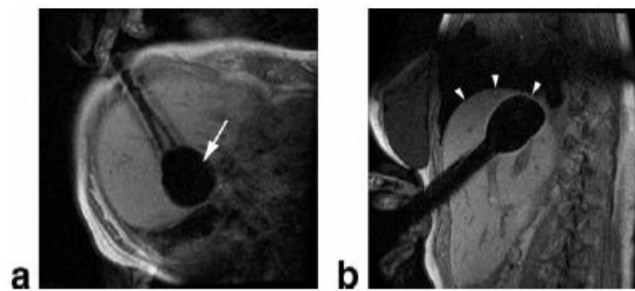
Ice ball visualisation during MRI aided cryosurgery [27]
